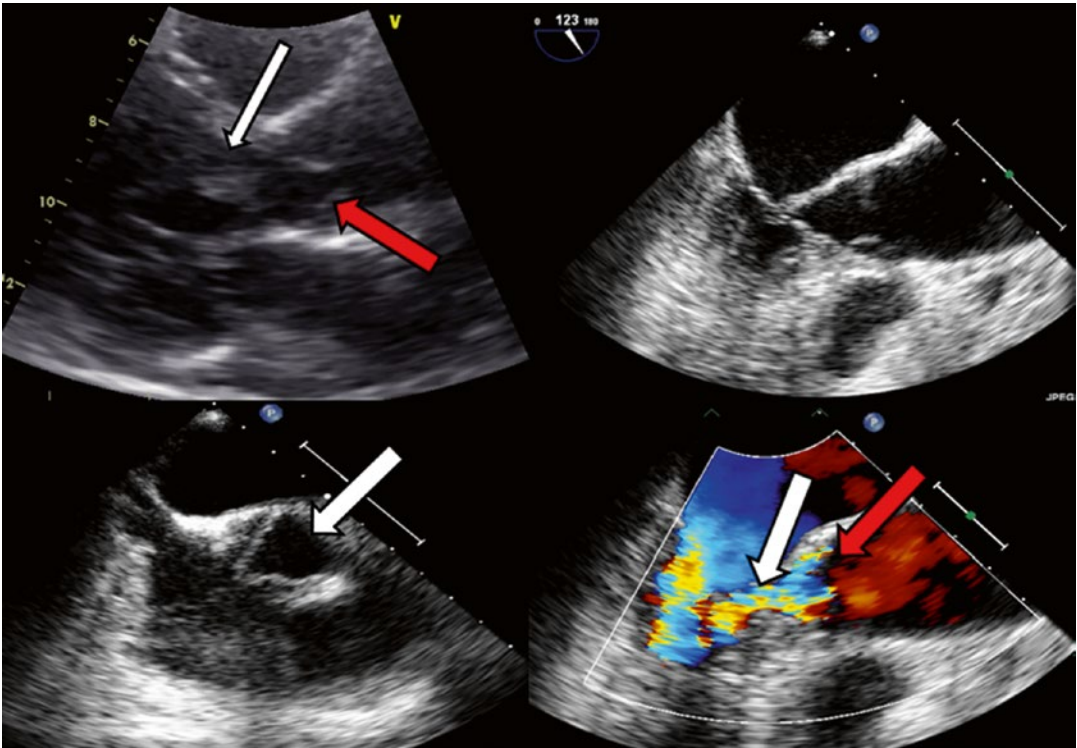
Case 4 patient TTE and TEE images. (Top left) TTE parasternal long axis showing aortic valve (red arrow) and LVOT obstruction. The white arrow shows the location of flow. (Top right) TEE LVOT view, showing aortic valve (red arrow) and again outflow obstruction
